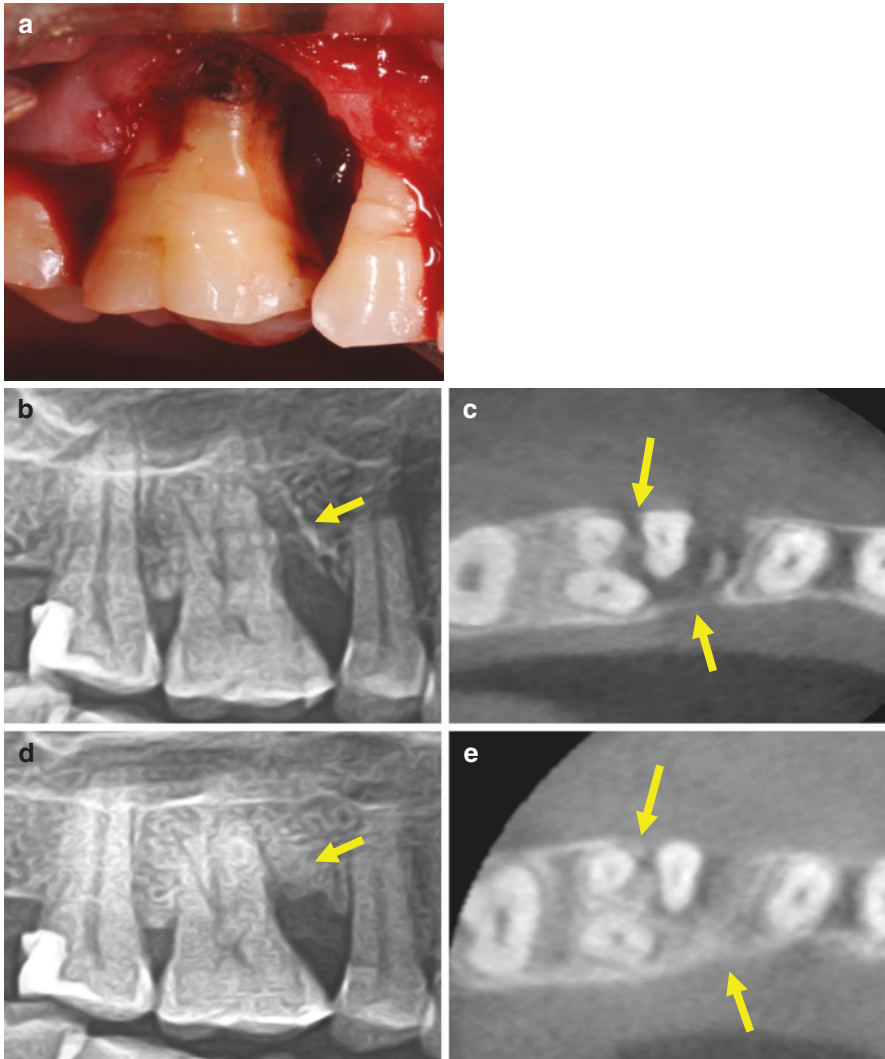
In this clinical case of the upper right first maxillary molar (a), one can see there is a Class III B-M furcal communication on both the periapical and CBCT cross-sectional view (b, c, arrows). After treatment, one can see radiographic fill for this defect (d, e, arrows). The corrective results are still stable 2 years after the surgical treatment
